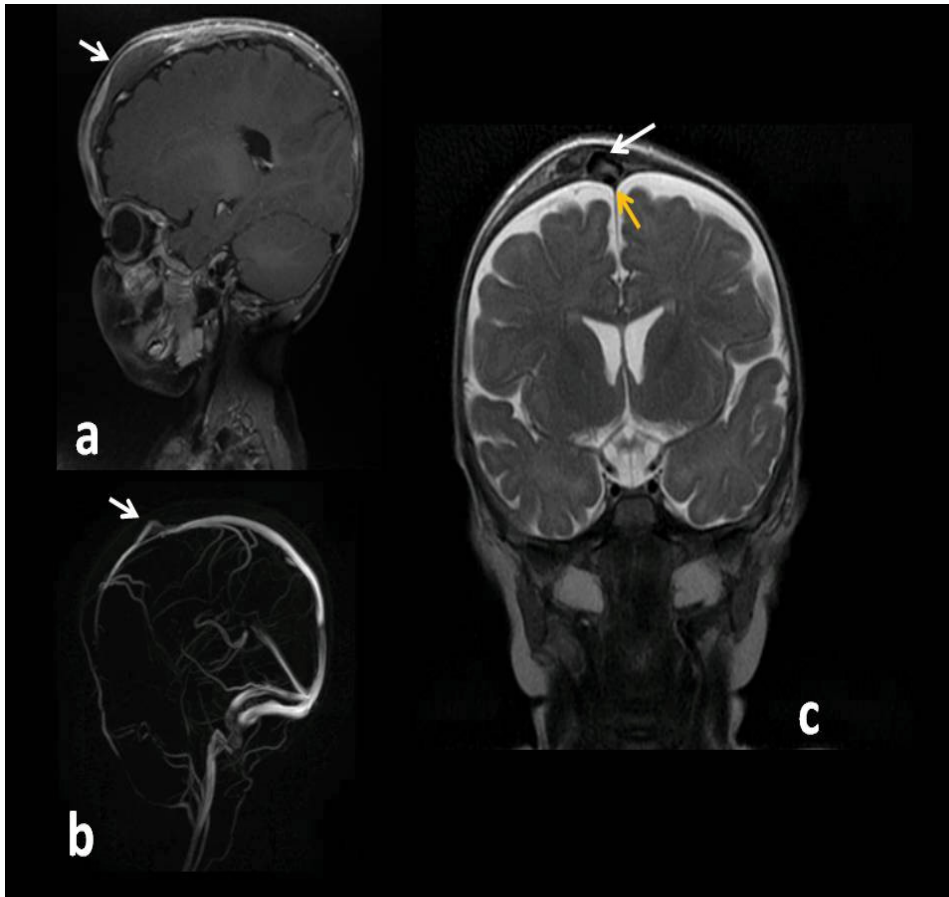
Magnetic resonance imaging: a) T1 sagittal picture with soft tissue enlargement (arrow) b) coronal T2 with hypointense signal lesion (signal void) (White arrow) indicating the presence of flow closely related to the superior sagittal venous sinus (yellow arrow). c) Venous angio-resonance study demonstrating the presence of flow inside the lesion and in connection with the superior sagittal sinus.
